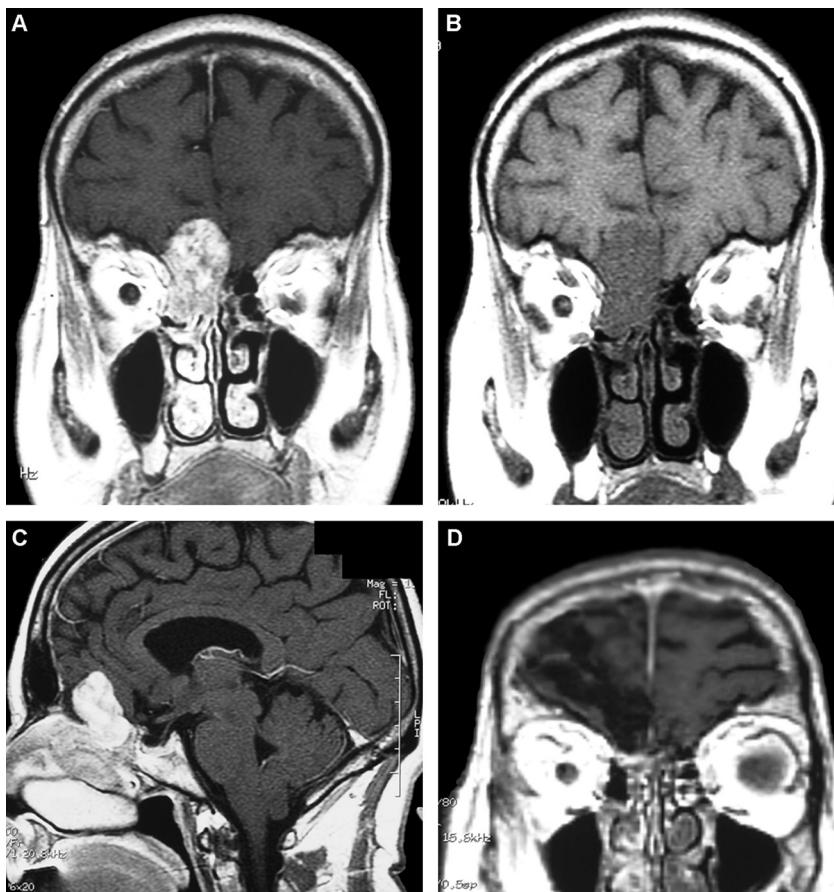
A. B. Preoperative T1 coronal MRI, showing the ethmoidal sinus extension of the tumor. C. Preoperative T1 weighted free gadolinium sagittal MRI. D. Immediate postoperative view on T1w MR-scan; complete removal.
